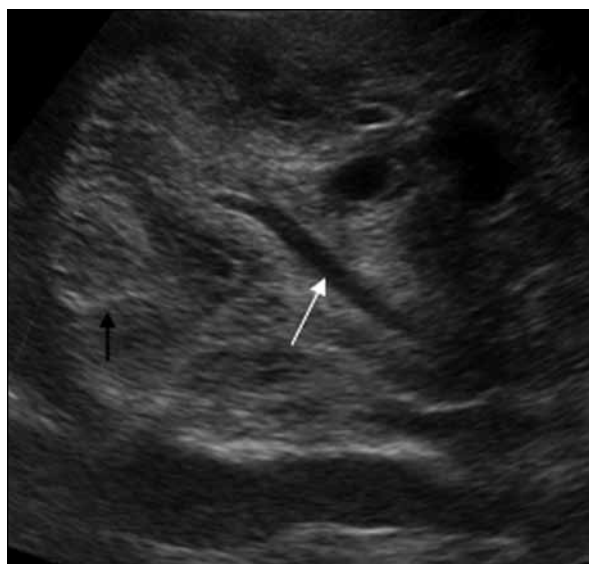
Grey-scale trasabdominal ultrasound (transverse scan) showing mosaic pattern/tortoise-shell pattern of hepatic schistosomiasis. Note the multiple thickened echogenic septa (black arrow) outlining polygonal areas of relatively normal-appearing liver parenchyma, and the portal vein (white arrow) surrounded by echogenic periportal fibrosis
